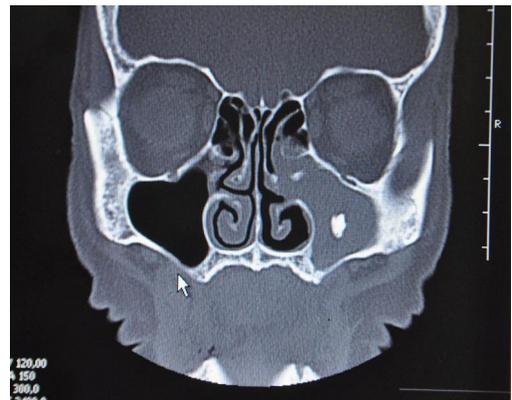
CT scan of the paranasal sinuses demonstrated complete opacification of the right maxillary sinus accompanied with a focal area of density comparable to bone; thus firstly it was considered as compatible with an ectopic molar tooth eruption which fills the base of right maxillary sinus.
